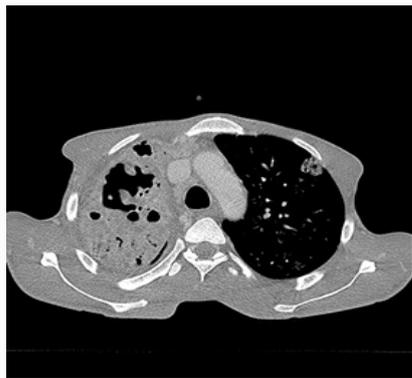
Images in a 46-year-old woman who presented with fever and productive cough. Axial thin-section unenhanced CT scan shows an increase in cavitative and colliquative phenomena, with super infection with *Aspergillus* spp.
